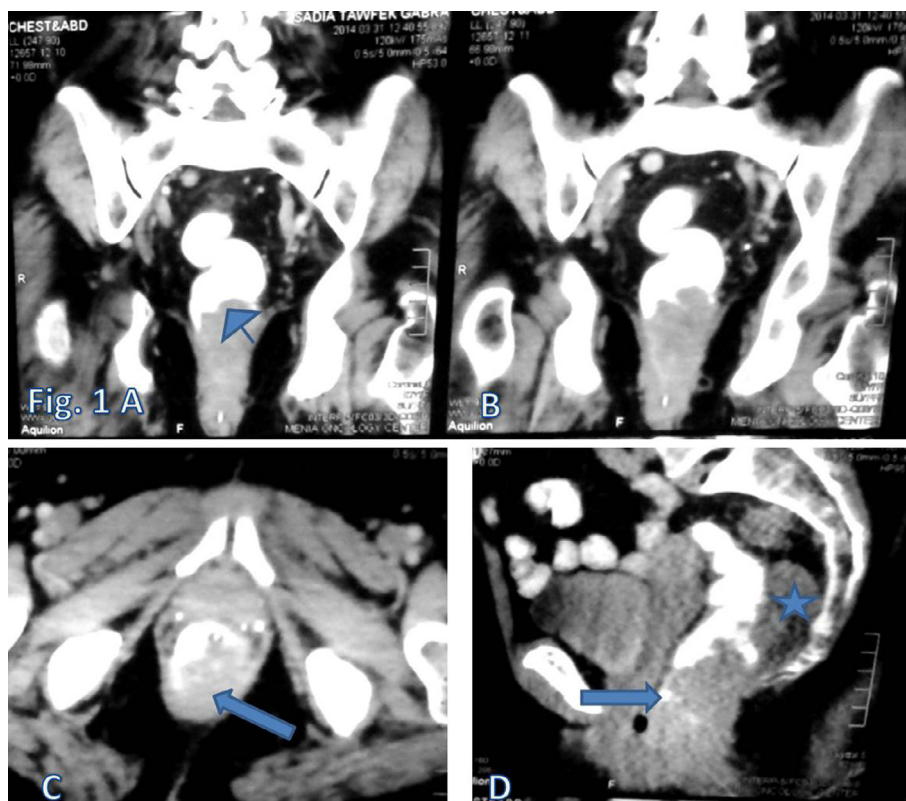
82 year old female patient: MDCT with endorectal contrast coronal MPR (A & B) revealed a large irregular soft tissue rectal mass lesion eccentric and markedly attenuating rectal lumen, proximal shouldering is seen (arrow on A). (C) Axial CT MDCT (MPR images) with endorectal contrast, the eccentric mass lesion is noted at the Lt. postero-lateral aspect (arrow). (D) Sagittal CT MPR images, here the lesion and mucosal destruction were noted with haziness of the peri-rectal fat planes, enlarged peri-rectal LNs were seen (asterisk on D), and the lesion was inseparable from the uterus anteriorly (arrow on D).
